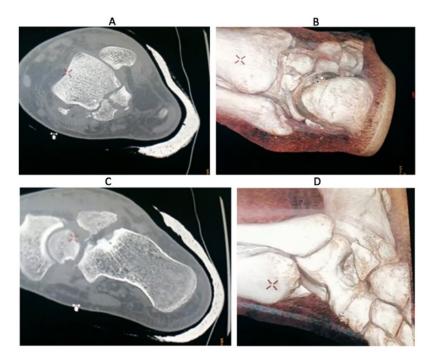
2A, 2B: CT scan shows entire posterior process talus fracture with comminution, 2C, 2D: CT scan anterior process calcaneal fracture.
